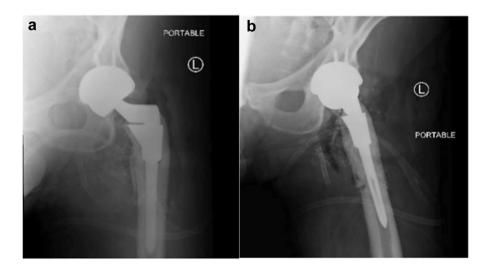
(a) Postoperative anteroposterior radiograph of the left hip. (b) Postoperative lateral radiograph demonstrating removal of hardware, debridement, and local antibiotic placement.
